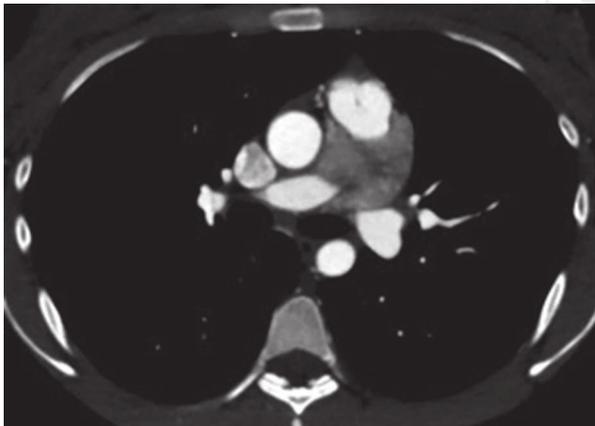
Coronary computed tomography. Mass surrounding the pulmonary artery.
